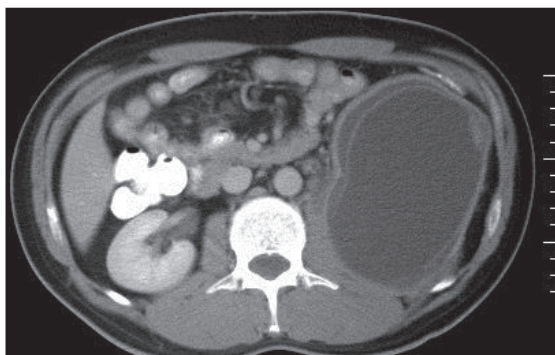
Large retroperitoneal cystic echinococcosis seen on upper abdominal CT image.
